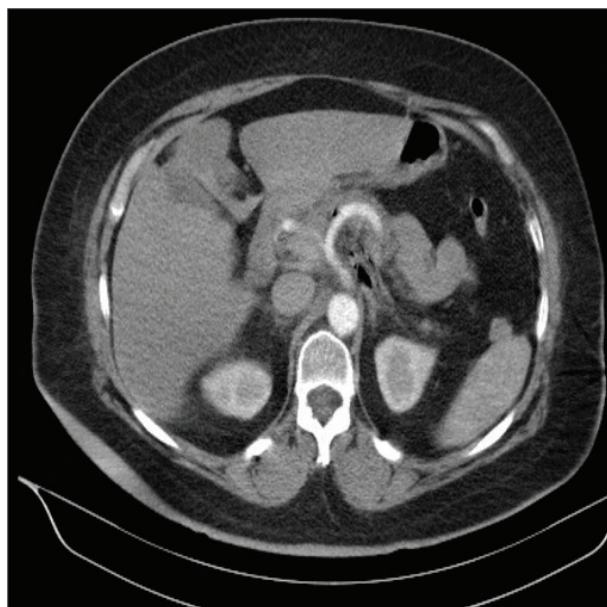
A CT scan taken immediately after IRE.
